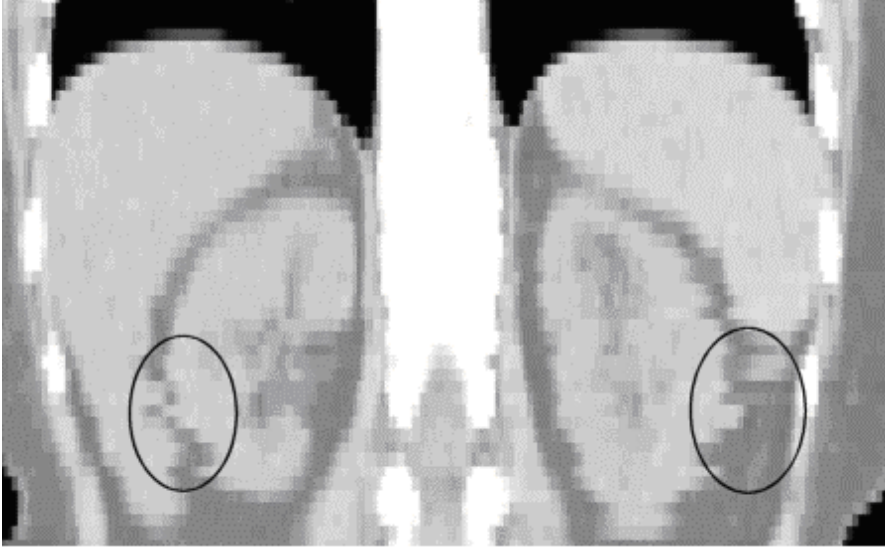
CT image of the kidneys with strong motion artifacts due to breathing. ROI is indicated.
